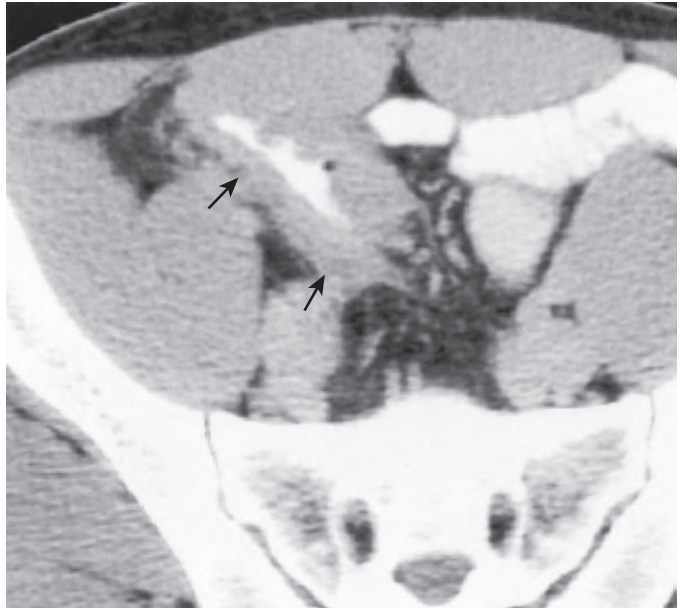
Cytomegalovirus infection in a patient with AIDS. CT through the pelvis shows marked wall thickening of the distal ileum (arrows). There also is irregularity of the mucosal surface caused by ulceration. (Courtesy Emil J. Balthazar, MD, and Hans Herlinger, MD.)
